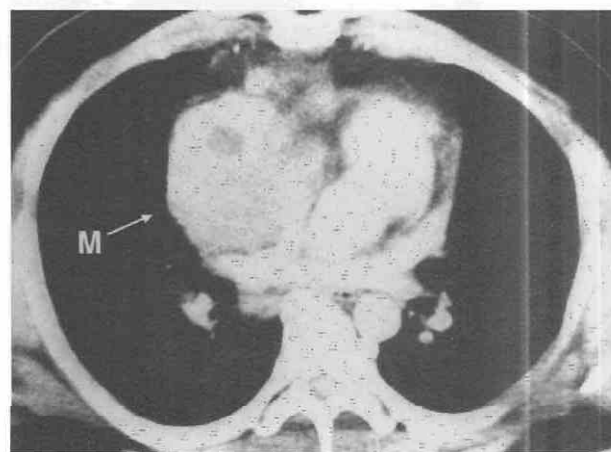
Seminoma. Contrast-enhanced CT shows anterior mediastinal mass (M) with a central area of low attenuation consistent with necrosis.
